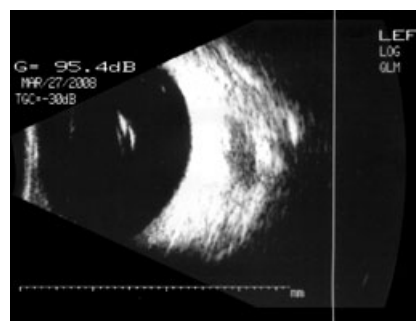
B-scan ultrasonography of the same eye as in Fig. 1 demonstrates a typical scattering with three hyperechoic opacities.
